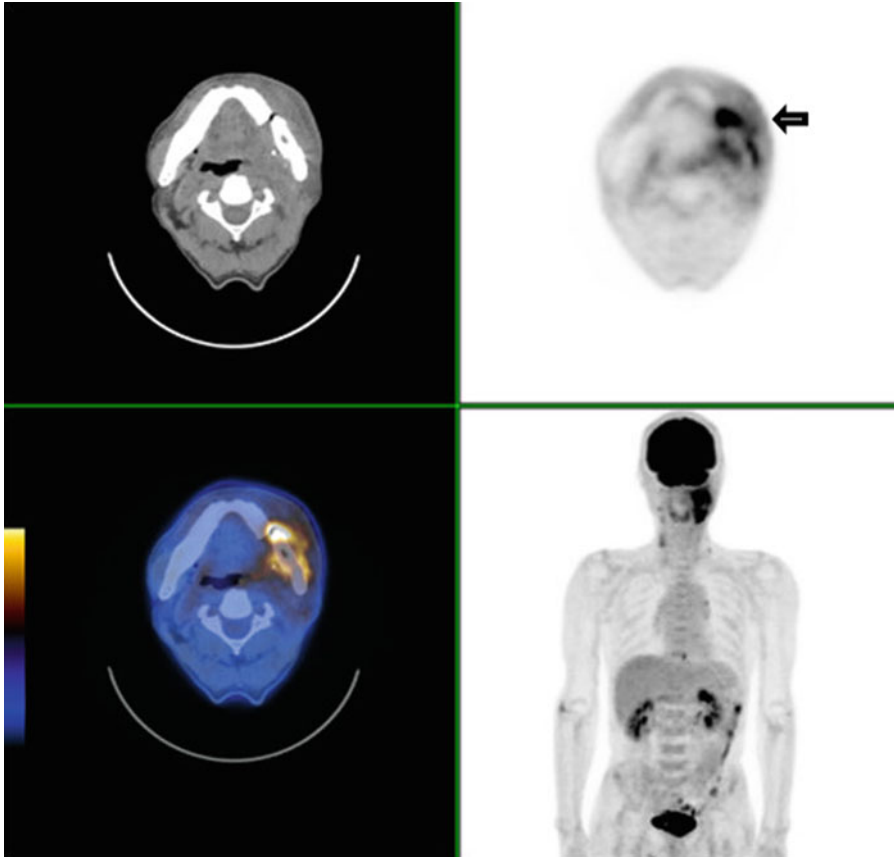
FDG PET/CT scan of a patient who had undergone partial mandibulectomy with reconstruction showed focal increased FDG uptake on the left mandible (*arrow*).
